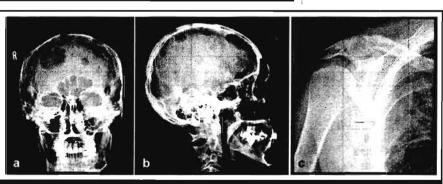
Radiographs taken on admission clearly showing lytic bone lesions. A) Skull AP. B) Skull lateral. C) Lytic lesion seen at the right acromioclavicular junction
